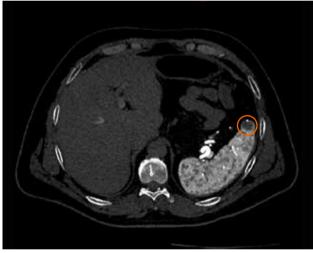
Axial slice of intra-arterial CT image showing splenic lesion
